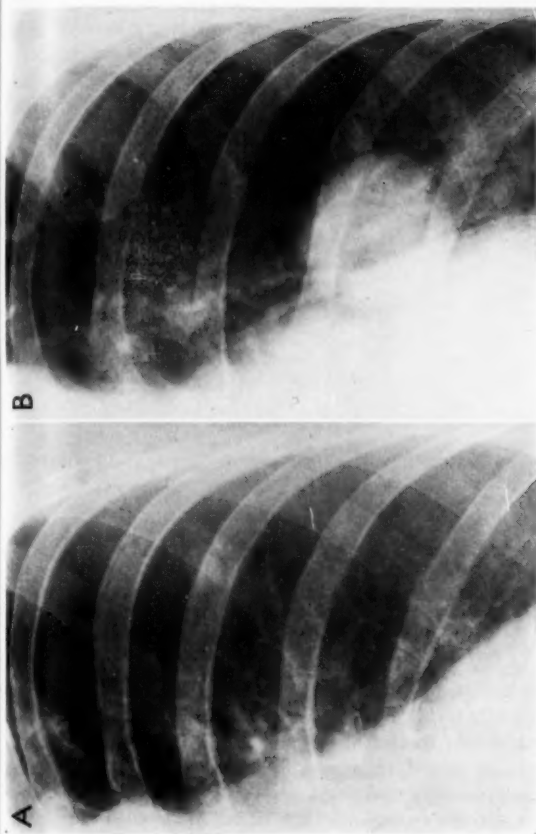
Roentgenographic example demonstrating the fallibility in attaching diagnostic significance to the size of a pulmonary nodule. The small circumscribed lesion in *A* measured less than 1 cm. in diameter but proved, at operation, to be a bronchial carcinoma. By contrast, the bulky lesion in *B*, measuring almost 6 cm. in diameter, turned out to be a granuloma containing *Histoplasma* (histoplasmosis).
